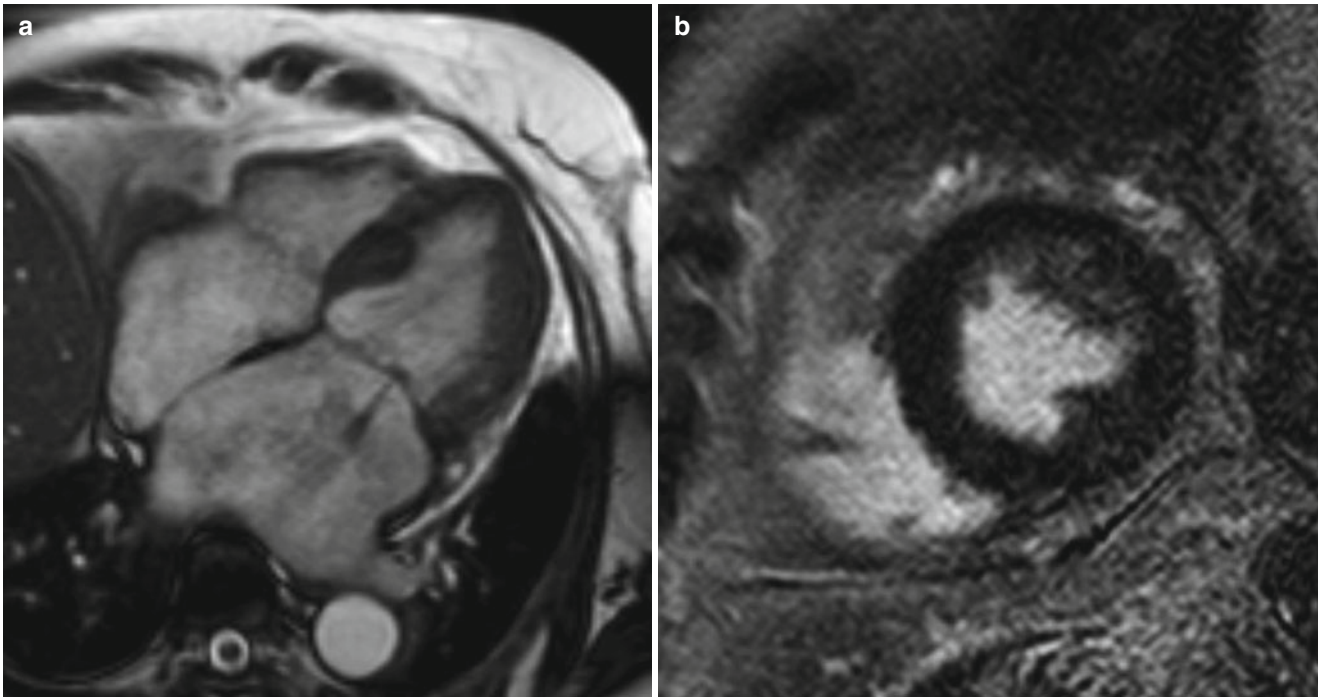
MRI of a patient diagnosed with idiopathic restrictive cardiomyopathy. (a) Four-chamber cine MRI shows normal-sized left ventricle with enlarged left atrium and mild mitral regurgitation. (b)
